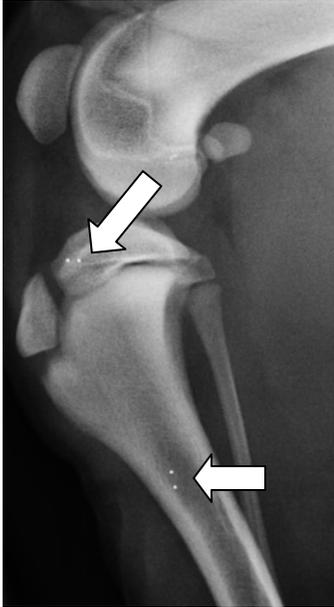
Lateral and cranio-caudal radiographs of the right stifle after tanatalum marker implantation. The arrows indicate the position of the 0.5 mm diameter markers.
